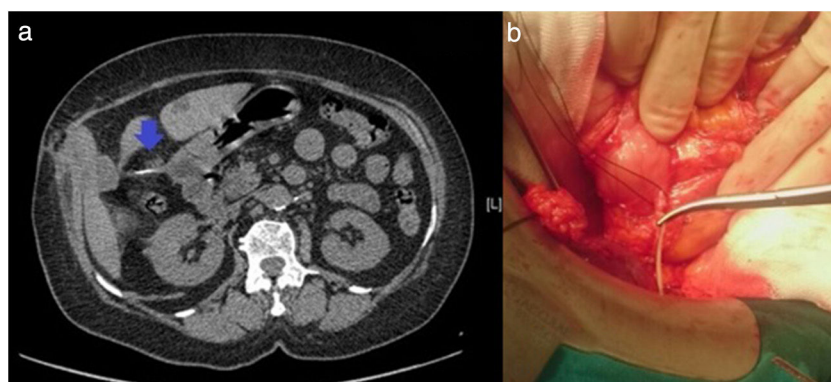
(a) Axial slice of the CT scan, showing a foreign body (fishbone, blue arrow); on the right; (b) intraoperative image where the bone is observed in the fistula tract to the liver. The figure colors can only be seen in the electronic version of the article.
